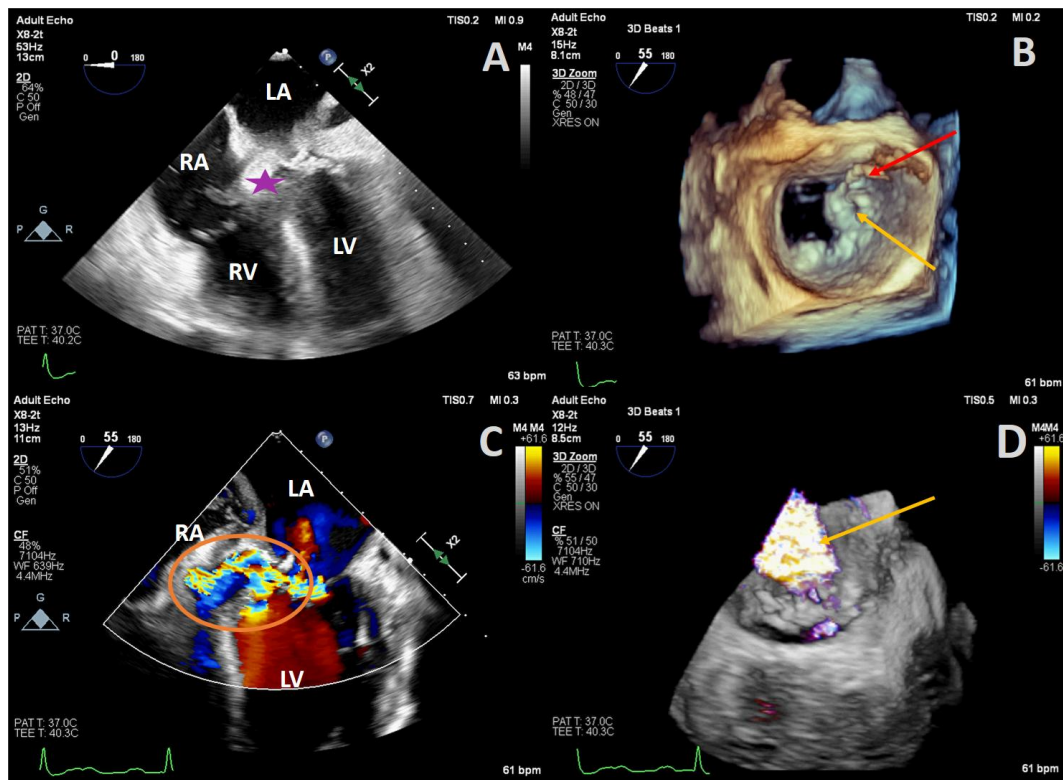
A) Lower esophageal four-chamber view showing coronary sinus abscess (purple star) with a vegetative extension into the right atrium. B) 3D en-face view demonstrating mitral annular perforation at the medial commissure, severe mitral annular calcification, and attached vegetations (red and yellow arrows). C) Bicommissural color Doppler view showing a pseudoaneurysm at the posteromedial commissure of the mitral valve and annulus (orange circle). D) 3D color Doppler imaging revealing severe mitral regurgitation originating from the perforated mitral annulus (orange arrow)
